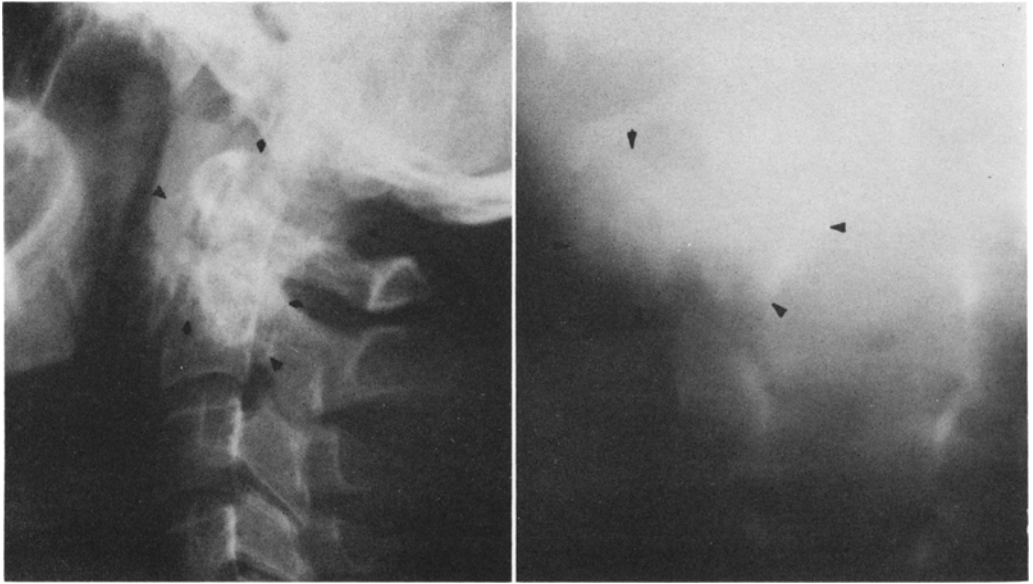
Left:* Plain film of the cervical spine, lateral view, showing stippled calcification of the tumor mass (*arrows*). *Right:* Anteroposterior tomogram demonstrates the extent of the tumor that appears to arise from the lateral mass of the axis.
